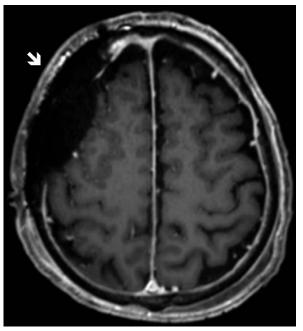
Post-operative MRI showed normal.
